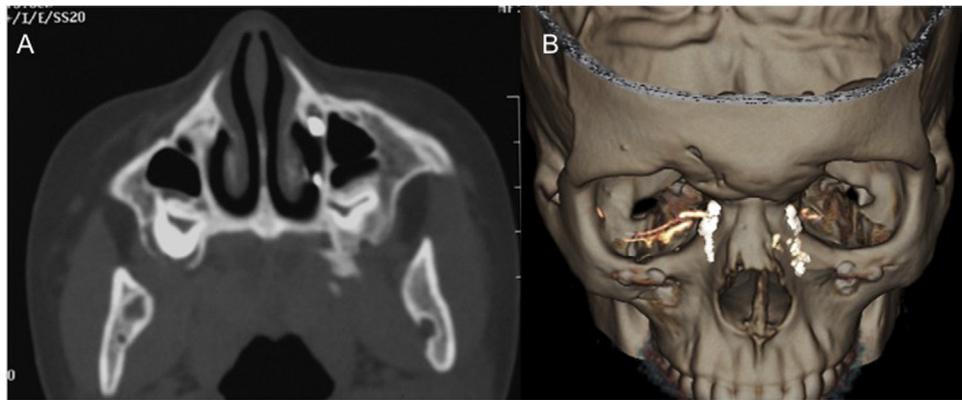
A & B, CT-DCG with 3D reconstruction shows a normal right lacrimal system and discontinuity beyond the lacrimal sac on the left side.
